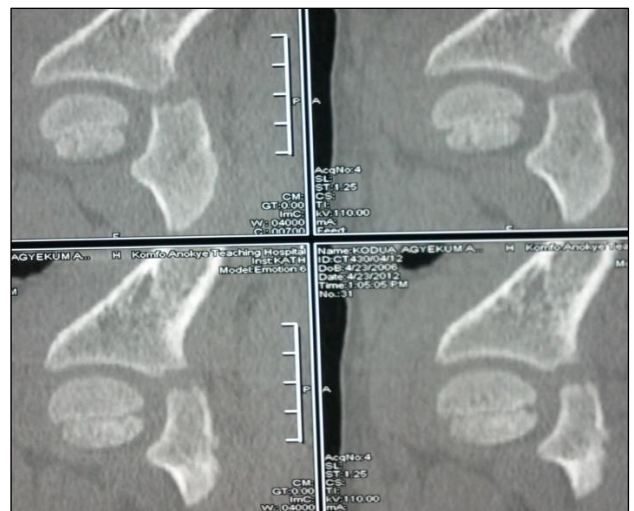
Sagittal view of CT scan of hip.
